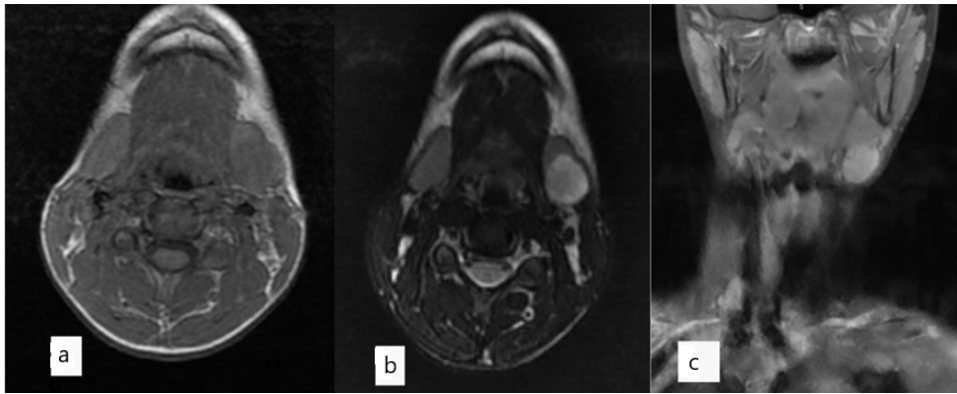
MRI shows right (a) hypointense submandibular mass in axial T1-weighted image sequence, (b) hyperintense in axial T2-weighted sequence, and (c) heterogenous contrast enhancement in contrast-enhanced series.
